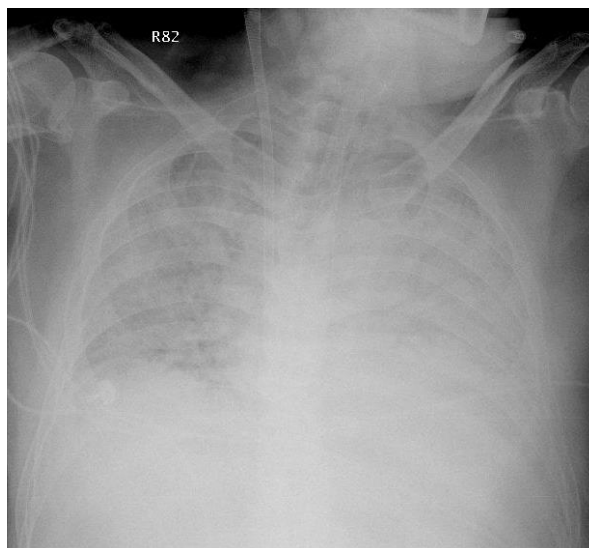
Chest roentgenogram on post-contrast day 1: Initiation of bilateral lung infiltration.
